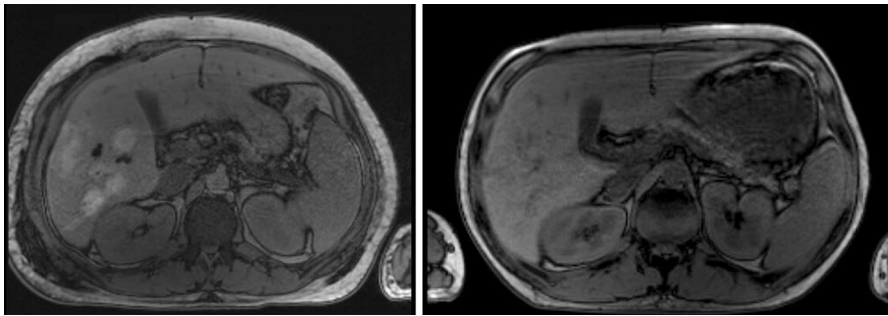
T1 MRI image of the  $6 \times 7.7 \times 9.3$  cm mass in the right inferior hepatic lobe with intrinsic T1 hyperintensity suggestive of hemorrhagic/proteinaceous contents and no central enhancement
